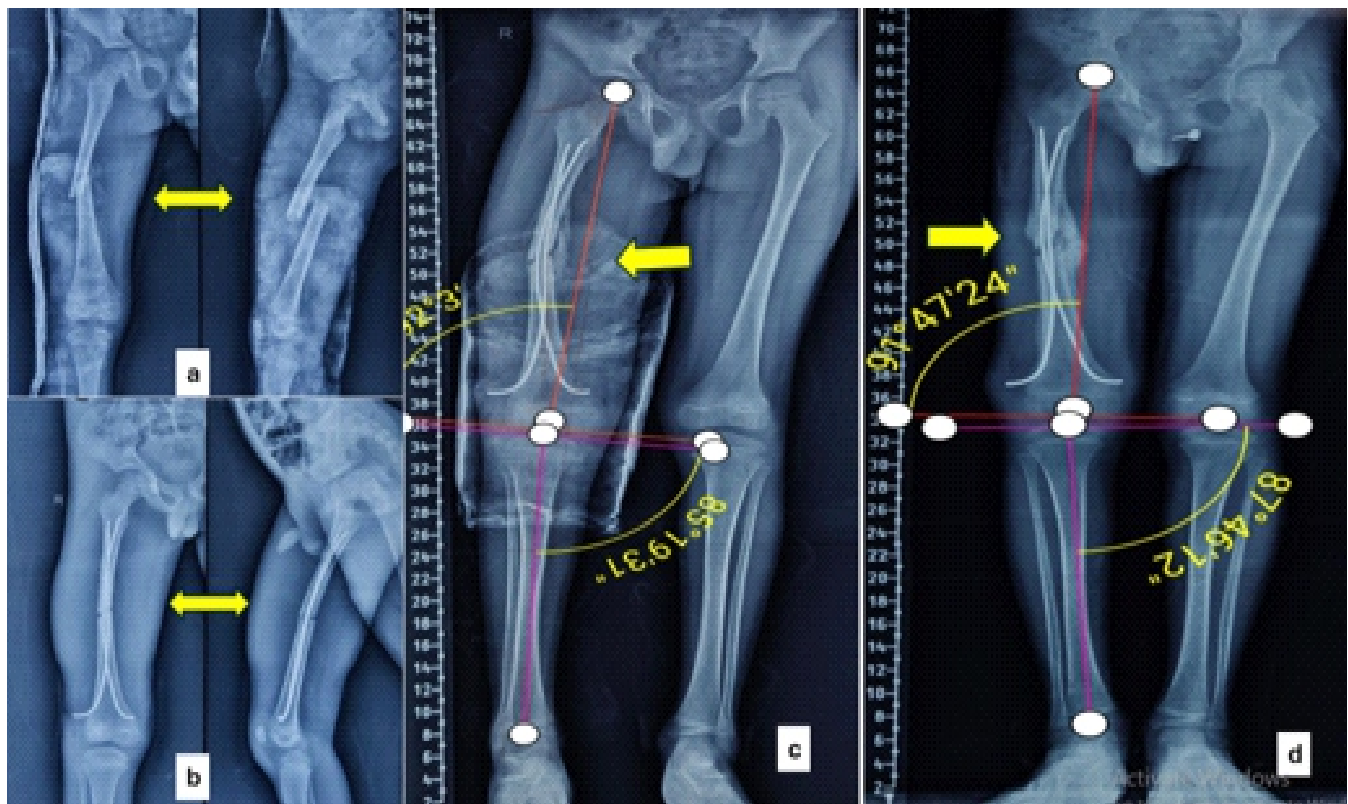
Example case: (a) Plain pre-operative anteroposterior (AP) and lateral view radiograph of a 9-year-old male child sustaining right femoral fracture (transverse type) following a fall from bed while playing. (b) Immediate post-operative X-ray AP and lateral views of the femur shaft after titanium elastic nailing system. (c) 8-week post-operative orthoscanogram showing callus formation (arrow marked). (d) 12-week post-operative orthoscanogram showing fracture union and findings consistent with approximately 2° of residual femoral varus deformity with no limb length discrepancy.
